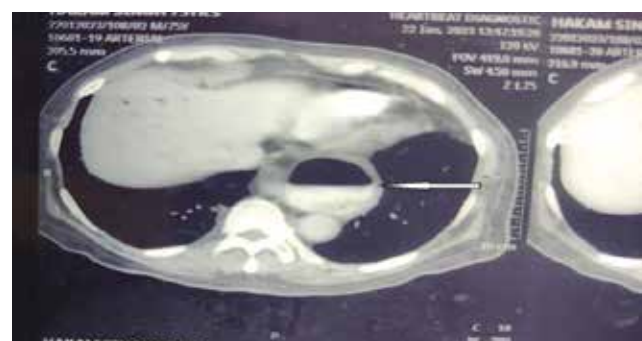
Contrast-enhanced computed tomography (CECT) axial section – diverticulum marked with white arrow.
